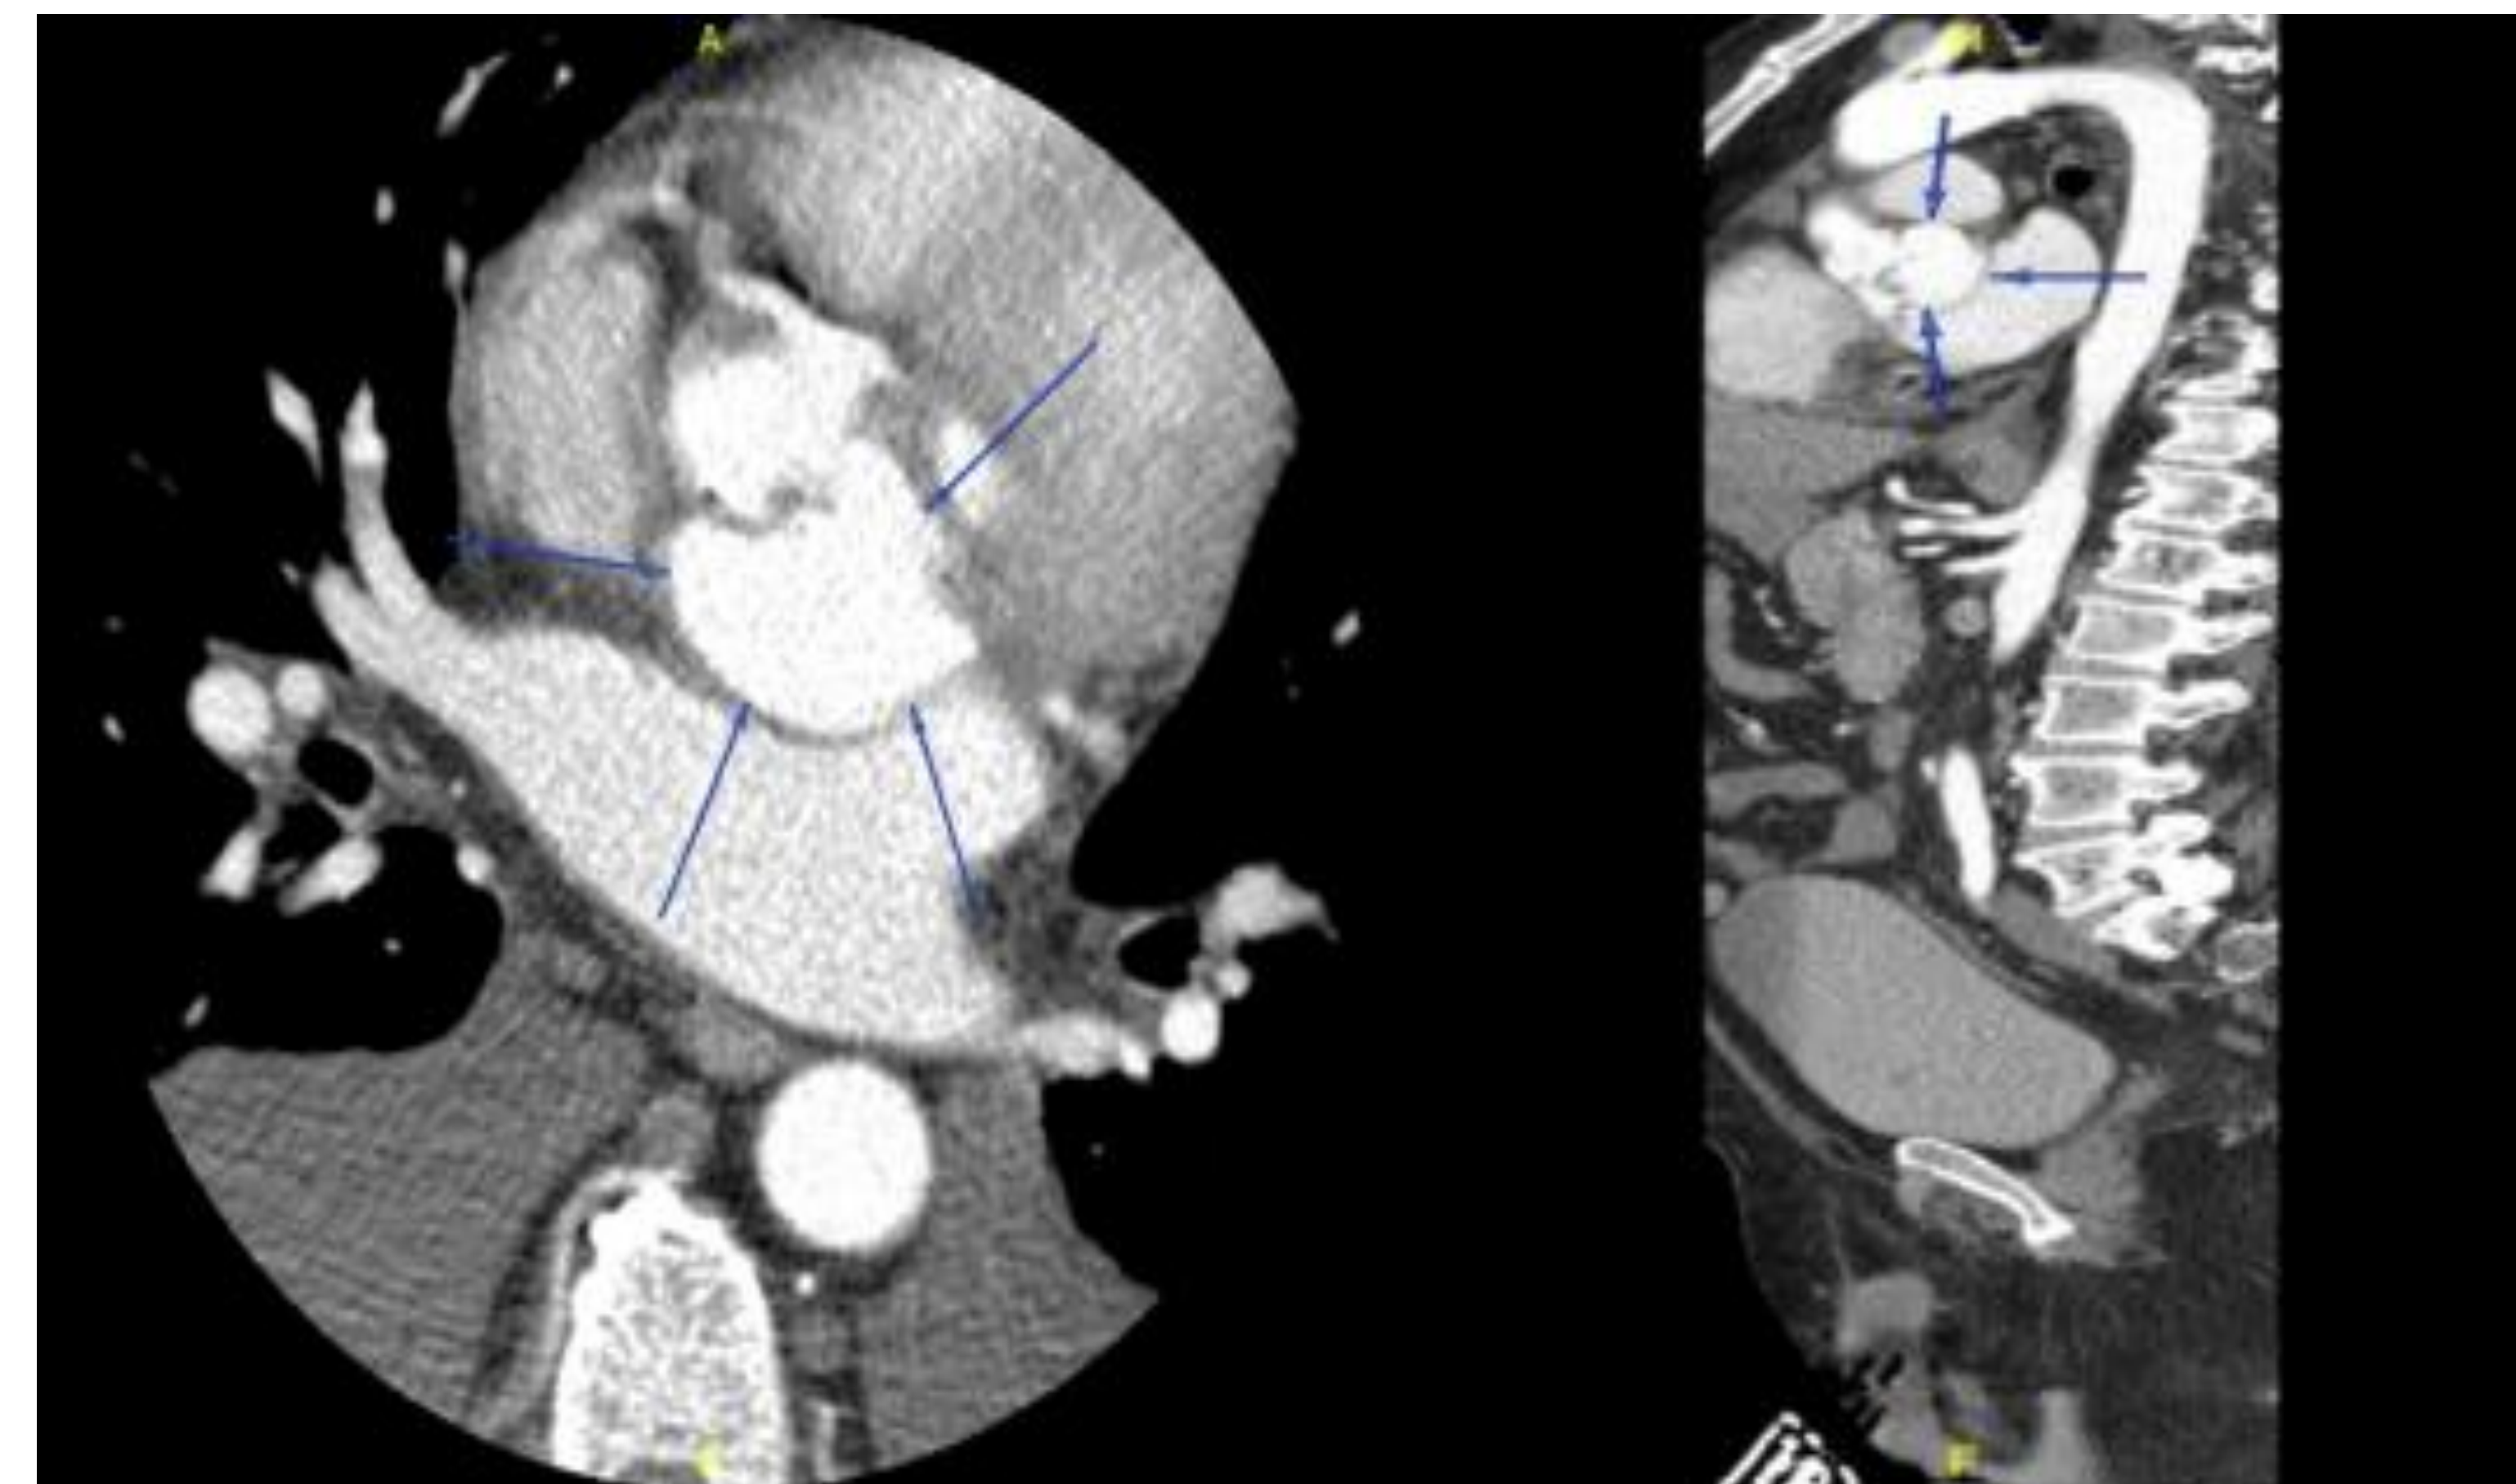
Cross-sectional view (A) and coronal view (B) of a CTA of the aorta demonstrating a 4.6 cm x 3.5 cm saccular outpouching along the posterior aspect of the aortic root and sinuses of Valsalva (thin arrows)
